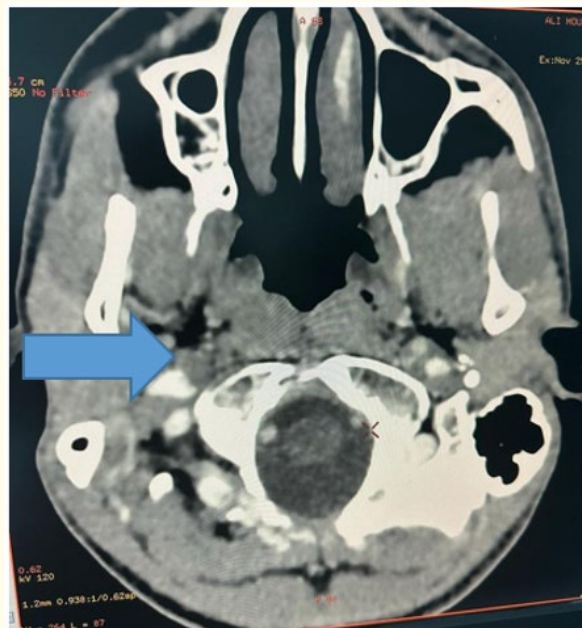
The CT brain angiography axial view shows occlusion of the right ICA.
